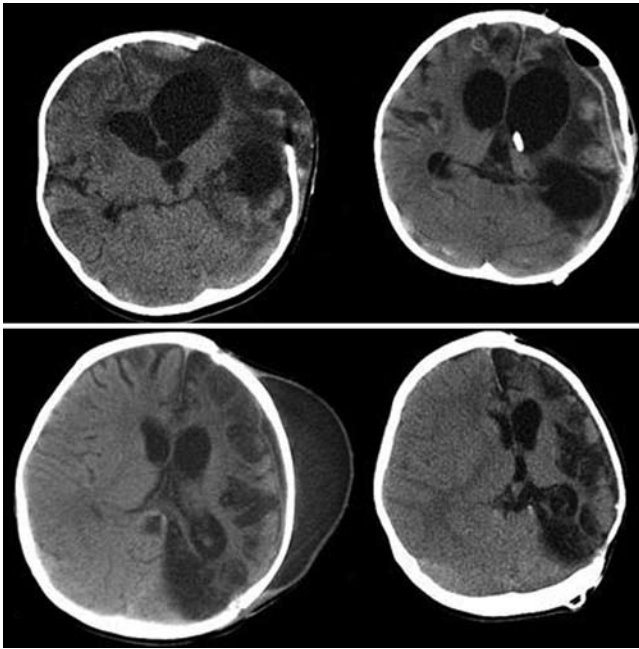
Cases 3 (upper) and 5 (lower). Noncontrast head CT scans obtained in 2 patients. Upper: Images showing enlargement of the ventricular system before (left) and after (right) placement of a left VPS and cranioplasty. Lower: Images showing a large subgaleal CSF collection before (left) and after (right) placement of a left VPS.
